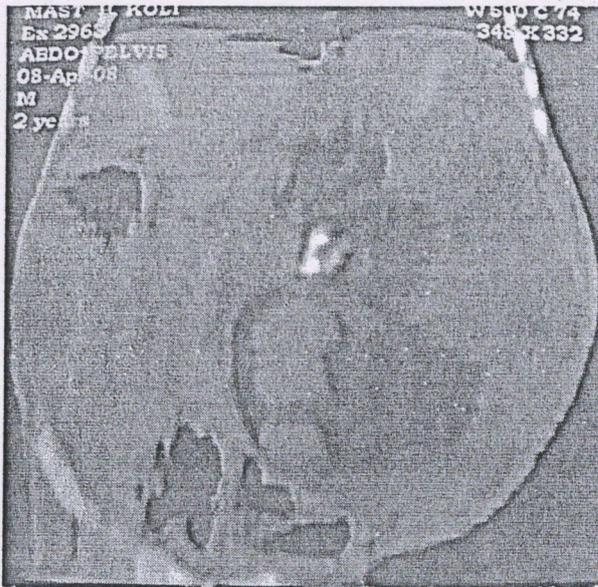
Case 1—CT scan showing mass in the abdomen with three vertebrae
